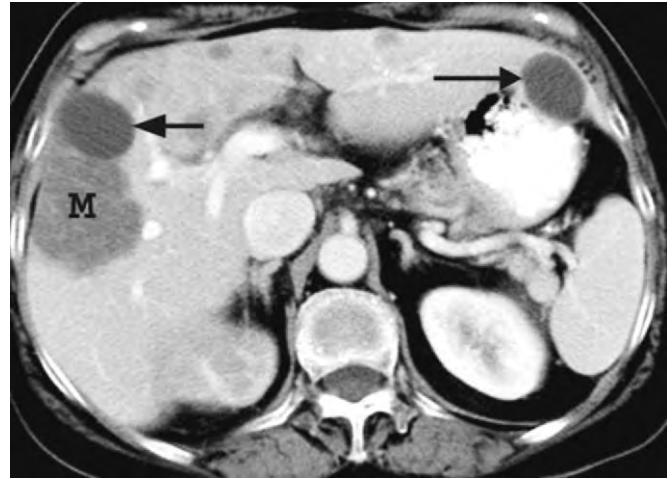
Two simple hepatic cysts and a liver metastasis. Transverse contrast-enhanced CT image shows two simple hepatic cysts (*arrows*) with water attenuation in the right and left lobes of the liver. The cysts are unenhanced and have imperceptible walls. Compare to the enhanced metastasis (M) adjacent to the cyst in the right lobe. Note several other small metastatic lesions in the liver.
